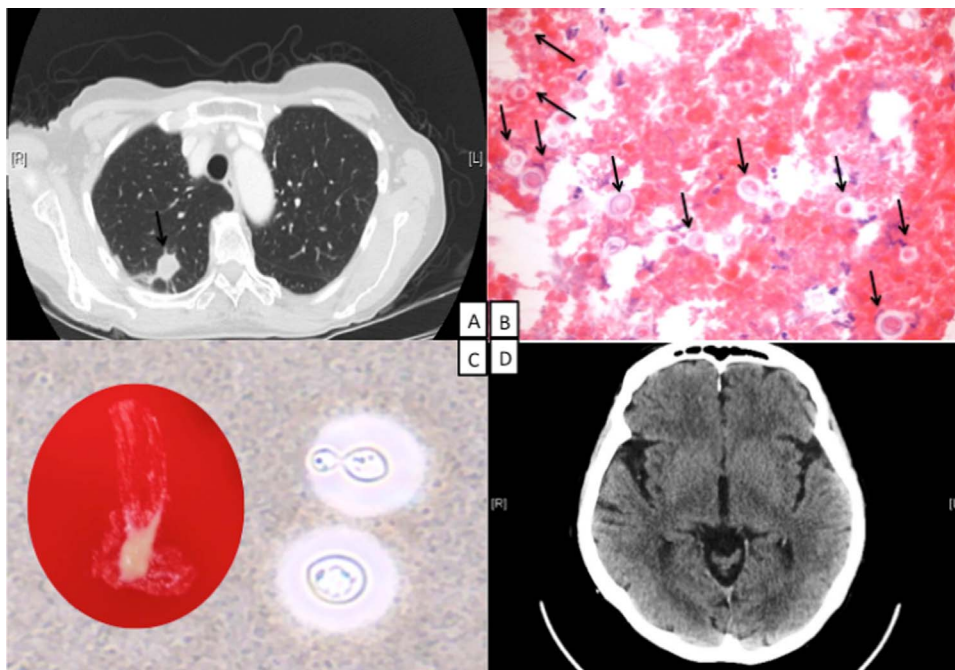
A. Right upper lobe nodule. B. Numerous encapsulated, budding yeasts on a paraffin frozen section of the lung nodule. C. India ink preparation showing encapsulated, budding yeasts containing volutin granules following 48 h growth on blood agar (insert). D. Normal brain on a non-contrasted axial head CT scan with no evidence of a space occupying lesion or midline shift.
